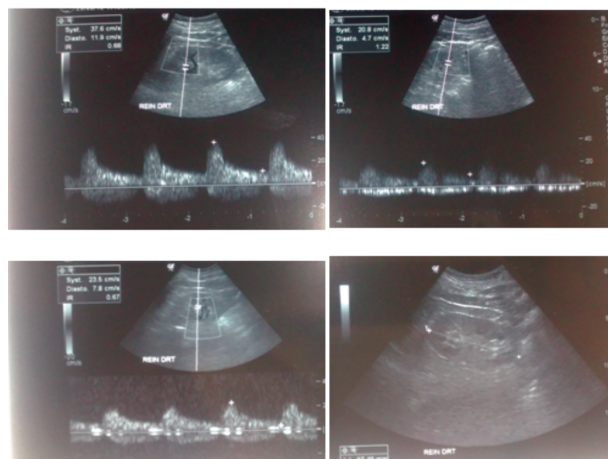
Renal artery doppler and renal ultrasound showing the absence renal artery stenosis and small kidneys.
